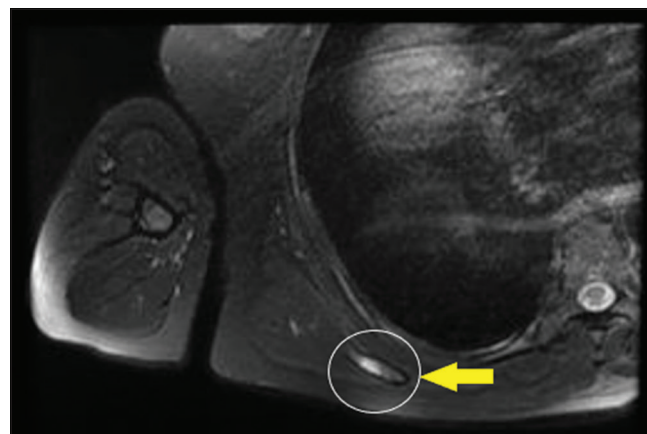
MRI view of the metastatic lesion located on the inferior angle of the right scapula
